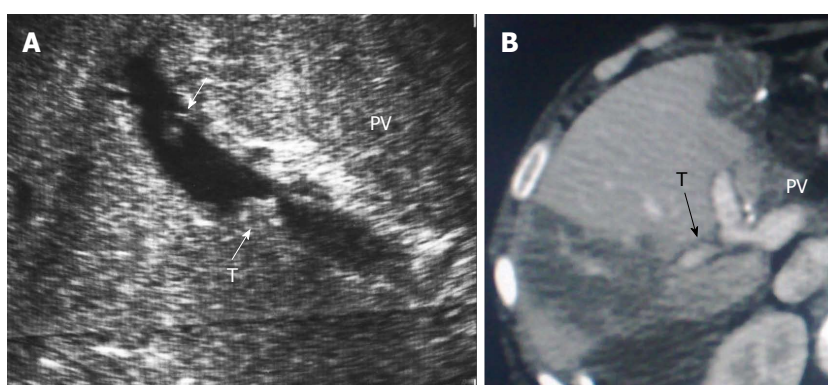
Post-operative portal vein segmental branch thrombosis and subsequent graft infarction, 2 wk post-living donor liver transplantation. A: B-mode US image showing multiple acute thrombi in the posterior segmental branch of the PV; B: Triphasic portal venous CT contrast study, demonstrating attenuated posterior branch of the PV with filling thrombus defect (arrow). Segmental portal infarction appears as wedge-shaped area of hypo-perfusion. PV: Portal vein; T: Thrombus.
